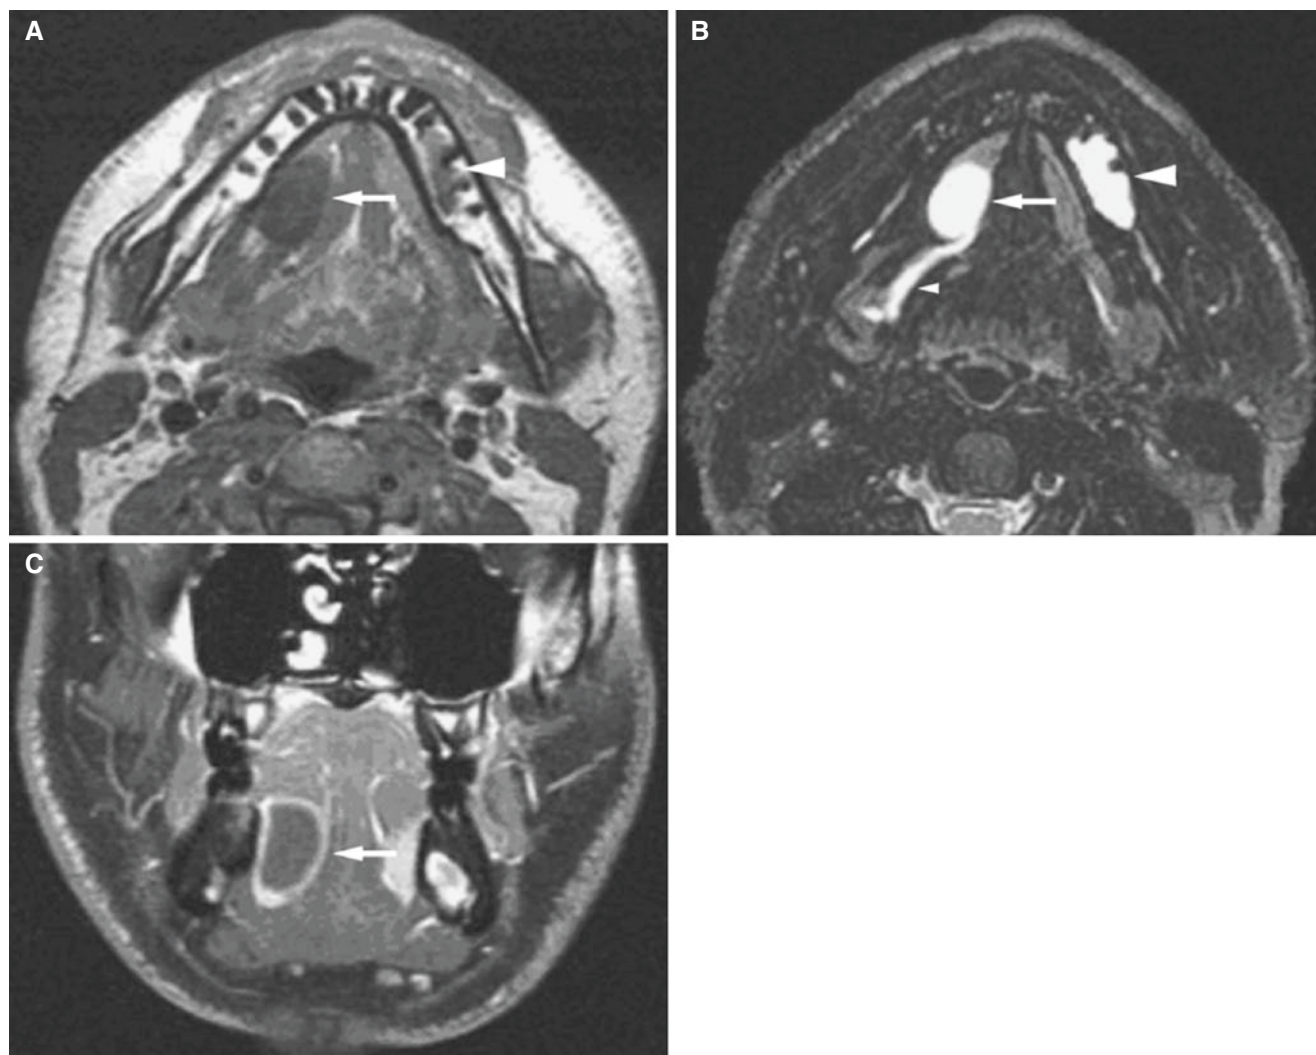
Sublingual (simple) ranula; 24-year-old male with a sublingual lump for about 2 months (clinical suspicion of neoplasm in the floor of the mouth), with incidental finding of a mandibular cyst. (A) Axial T1-weighted MRI shows well-defined oval low-signal area in the floor of the mouth on the right side (*arrow*) and low-signal marrow in a region of the left mandible (*arrowhead*). (B) Axial T2-weighted
